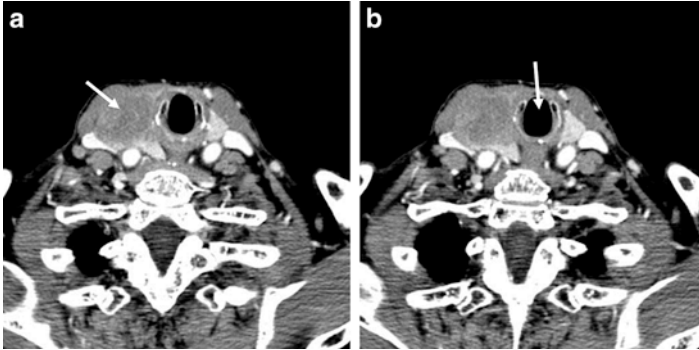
(a) CT scan. Large cervical mass due to a thyroid lymphoma (*arrow*). (b) The trachea is displaced toward the left side but the airway lumen is only minimally restricted (*arrow*). Several pathologic lymph nodes are also present
